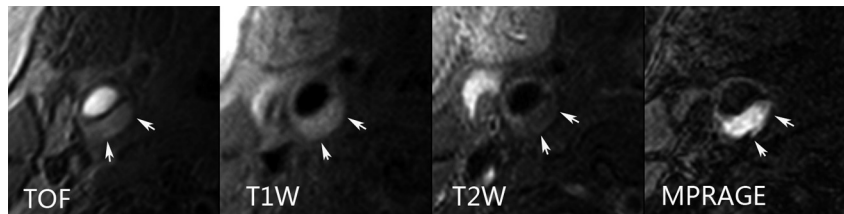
A large complicated plaque can be seen in the left common carotid artery of a 77-year-old male patient who experienced ipsilateral recurrent acute ischemic stroke. Inhomogeneous signal intensity (arrows) on TOF, T1-weighted, and T2-weighted images indicates LRNC with IPH and fibrous cap rupture. The hemorrhage was depicted more clearly by MPRAGE images.
